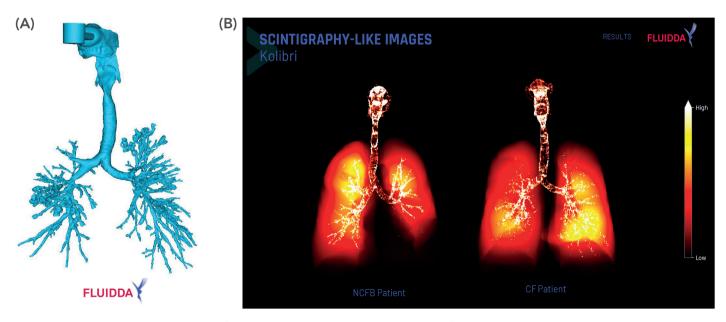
Reverse engineered CT scan of Kolibri™ virtually coupled to the mouth of a CF patient (A); FRI predicted lung deposition in scintigraphy-like images (B).
